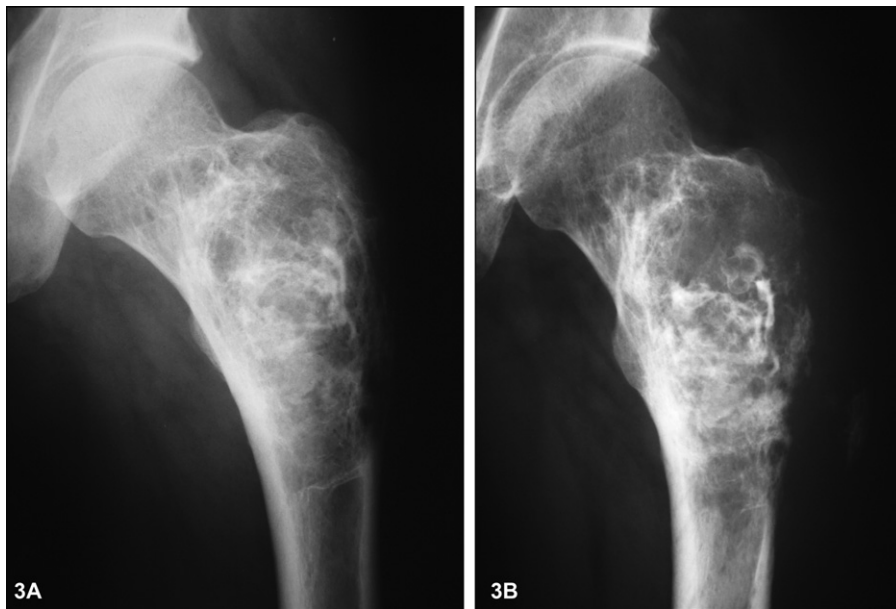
Case 4: (A) Bone cyst curetted and grafted, February 1970. (B) January 1990. Malignant Fibrous Histiocytoma: on the lateral radiograph, the lateral part of the cortex has completely disappeared.
